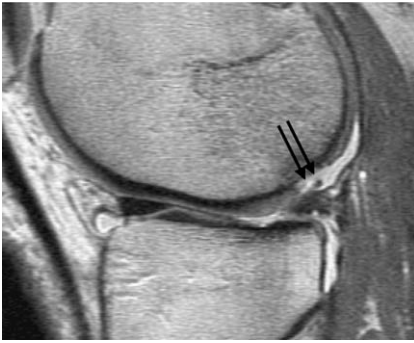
Standard two-dimensional FSE pulse sequence. A sagittal MR image demonstrates the focal cartilage defect at the posterior aspect of the femoral condyle (arrows).
